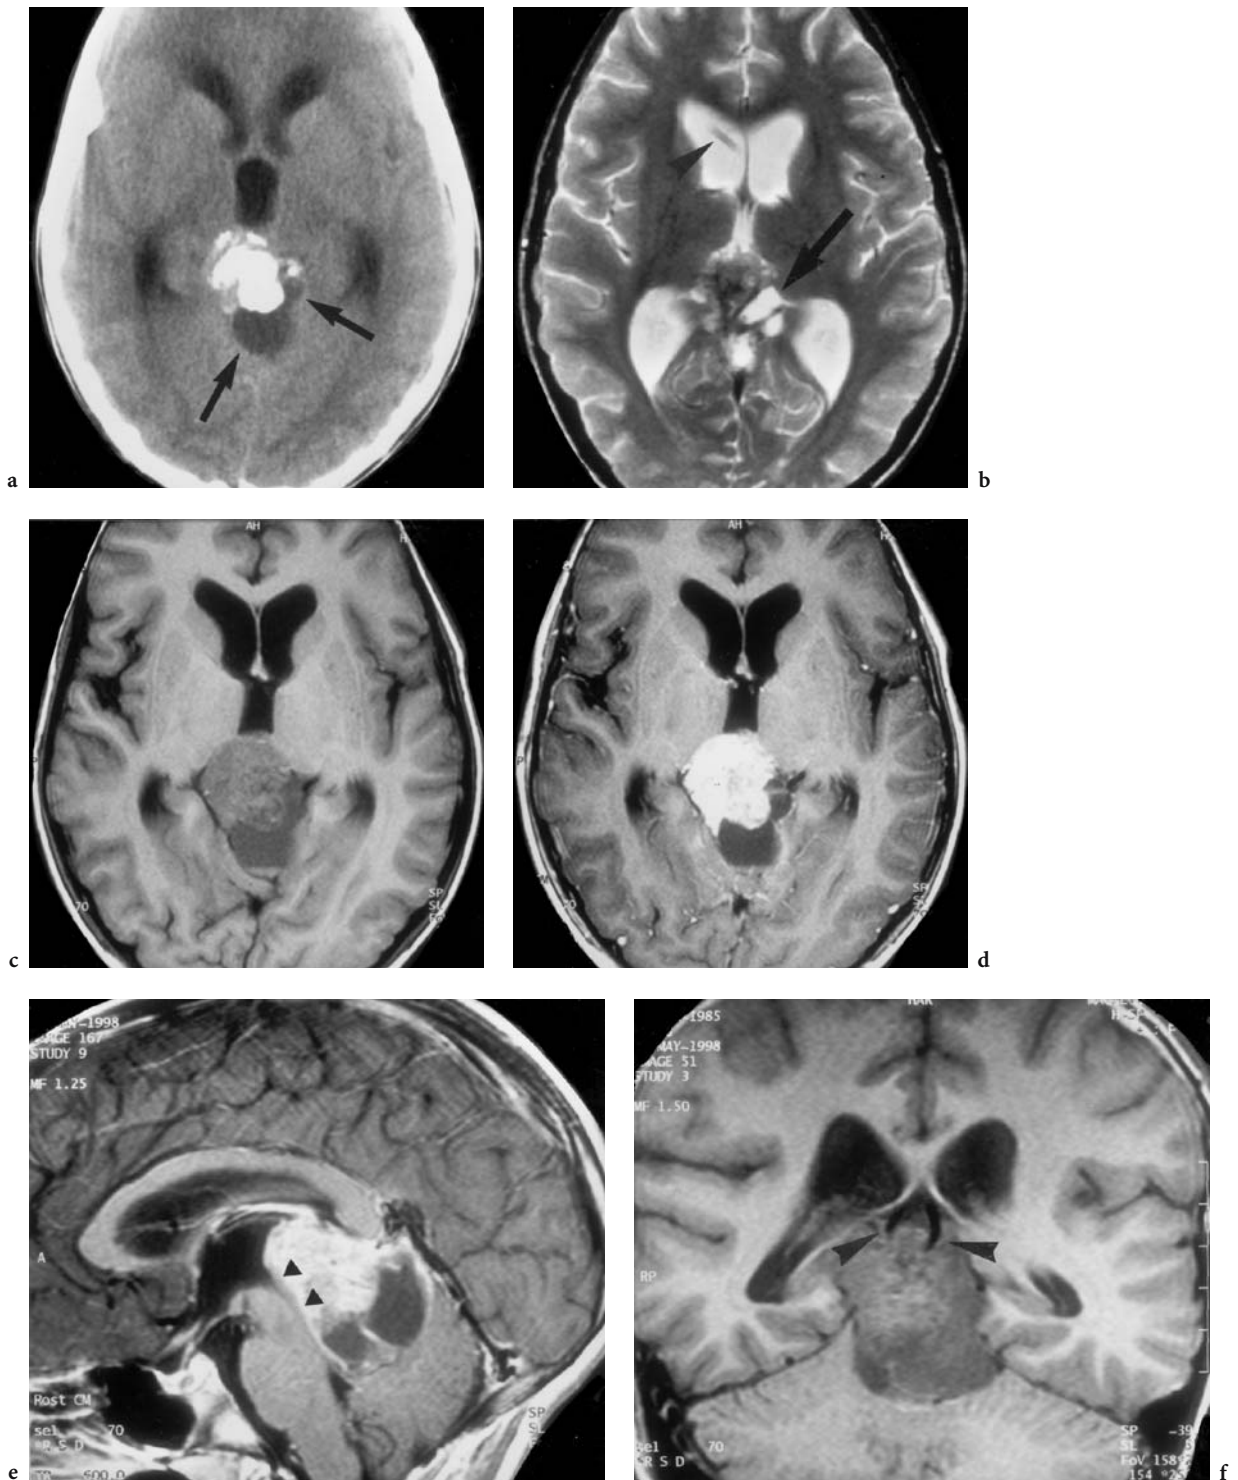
A 12-year-old boy with horizontal gaze paralysis (Parinaud's syndrome) and headache with drowsiness. Diagnosis: pinealoblastoma. CT: a Axial native view demonstrating occlusive hydrocephalus caused by a solid calcified tumor of the pineal region with cystic compartments (*arrows*); no significant contrast enhancement (not shown). MRI: b Corresponding T2-weighted image. The calcifications are identified by signal void, the cystic tumor region (*arrow*) is localized on the left, lateral to the expanded internal cerebral veins. Note normalization of ventricle lumen (best seen at the third ventricle) after emergency ventricular drainage (*arrowhead*). c Axial T1-weighted native view showing the relation of solid and cystic tumor part extending to the cistern of Galen's vein, the solid part depressing the posterior wall of the third ventricle and both pulvinar of the thalamus. d Corresponding contrast-enhanced image where, in contrast to CT, signal enhancement is bright. e Midsagittal, T1-weighted, contrast-enhanced view, impressively demonstrating the entire extension of the lesion. Note flattening of the quadrigeminal plate, seen as an isointense, small, post-aqueductal structure (*small arrowheads*), in addition to the infratentorial extension with depression of the upper vermis by the tumor cyst. f Coronal T1-weighted native image demonstrating the supra- and infratentorial growth with expansion of the internal cerebral veins (*arrowheads*) and lateral extension to the atrium of the right lateral ventricle
